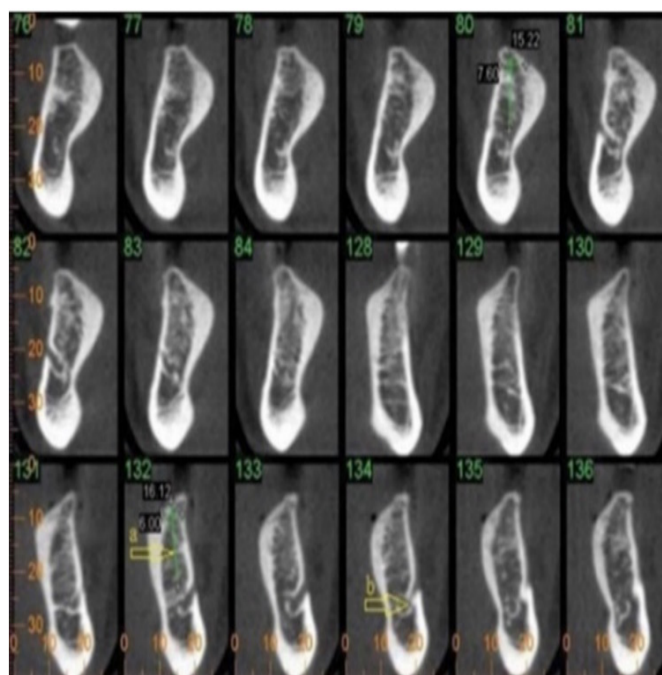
Representative cross-sectional CBCT image. The image was presented to participants as an example in the radiological terminology question and does not contain any personally identifiable information.
